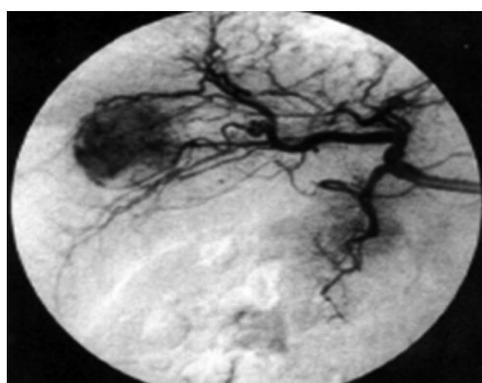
Hepatic angiography. Typical hyper-vascular pattern, corresponding to the findings of enhanced Doppler study, is clearly demonstrated by angiography^[77].
